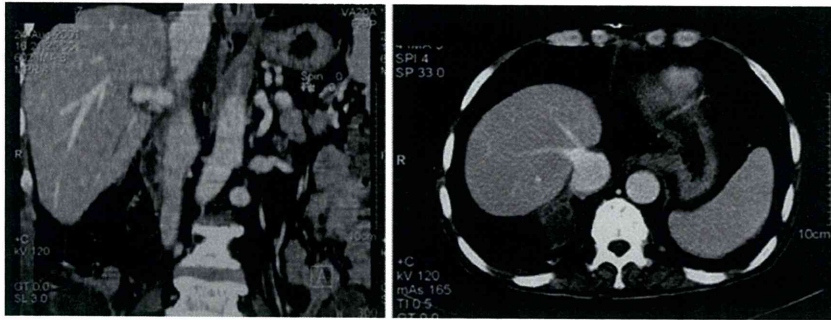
Follow-up abdominal CT confirmed a patent IVC with no signs of recurrent thrombus
